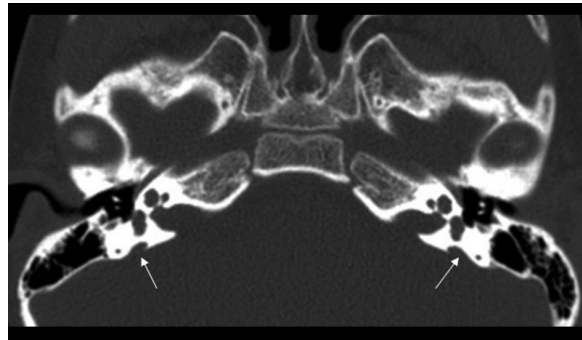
Axial CT image of the temporal bones in a 5-year-old boy with Pendred syndrome; white arrows point to bilaterally enlarged vestibular aqueducts
